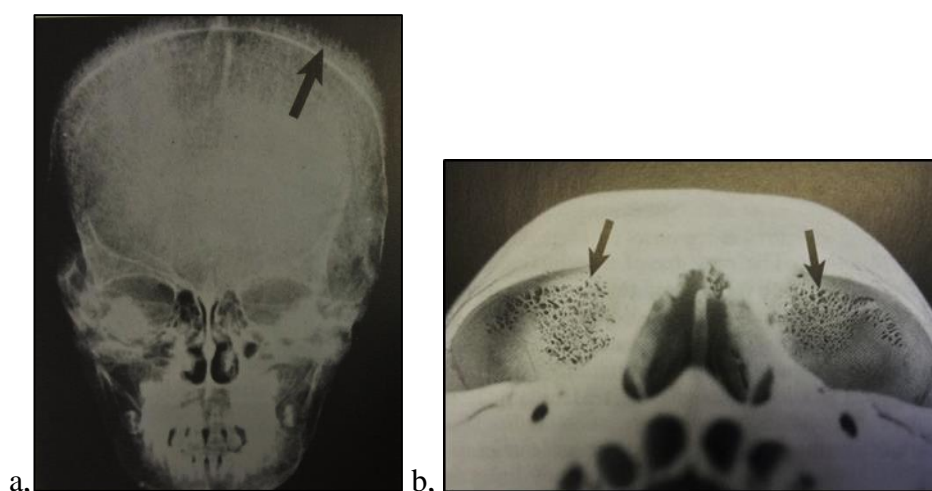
Porotic hyperostosis cranial and orbital lesions. a, ‘Hair-on-end’ on a skull radiograph (Calvin Wells Photographic Collection; from Roberts and Manchester 2010, 230); b, bilateral cribra orbitalia (National Museum of Natural History; from Roberts and Manchester 2010, 231)
